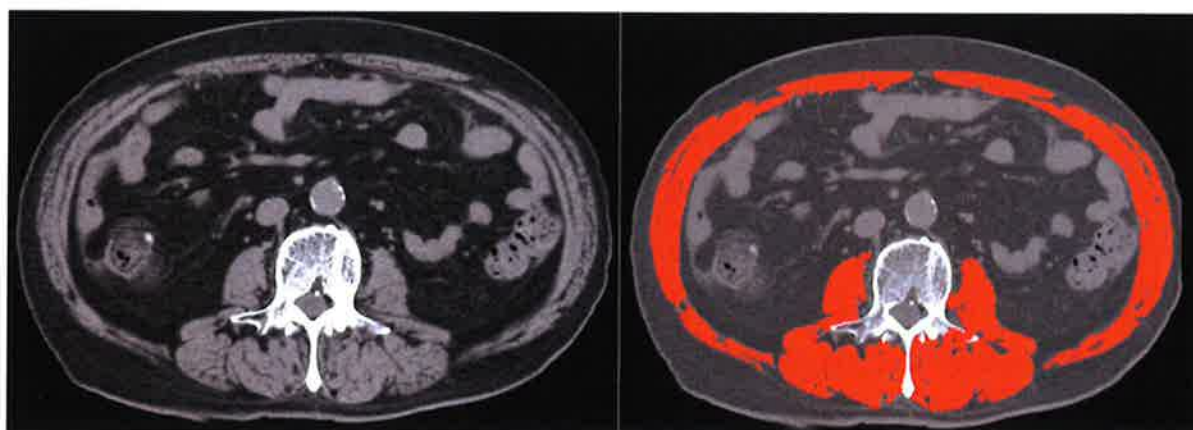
One CT-image at L3 before (left) and after (right) marking the muscles by the Slice O' Matic software.
